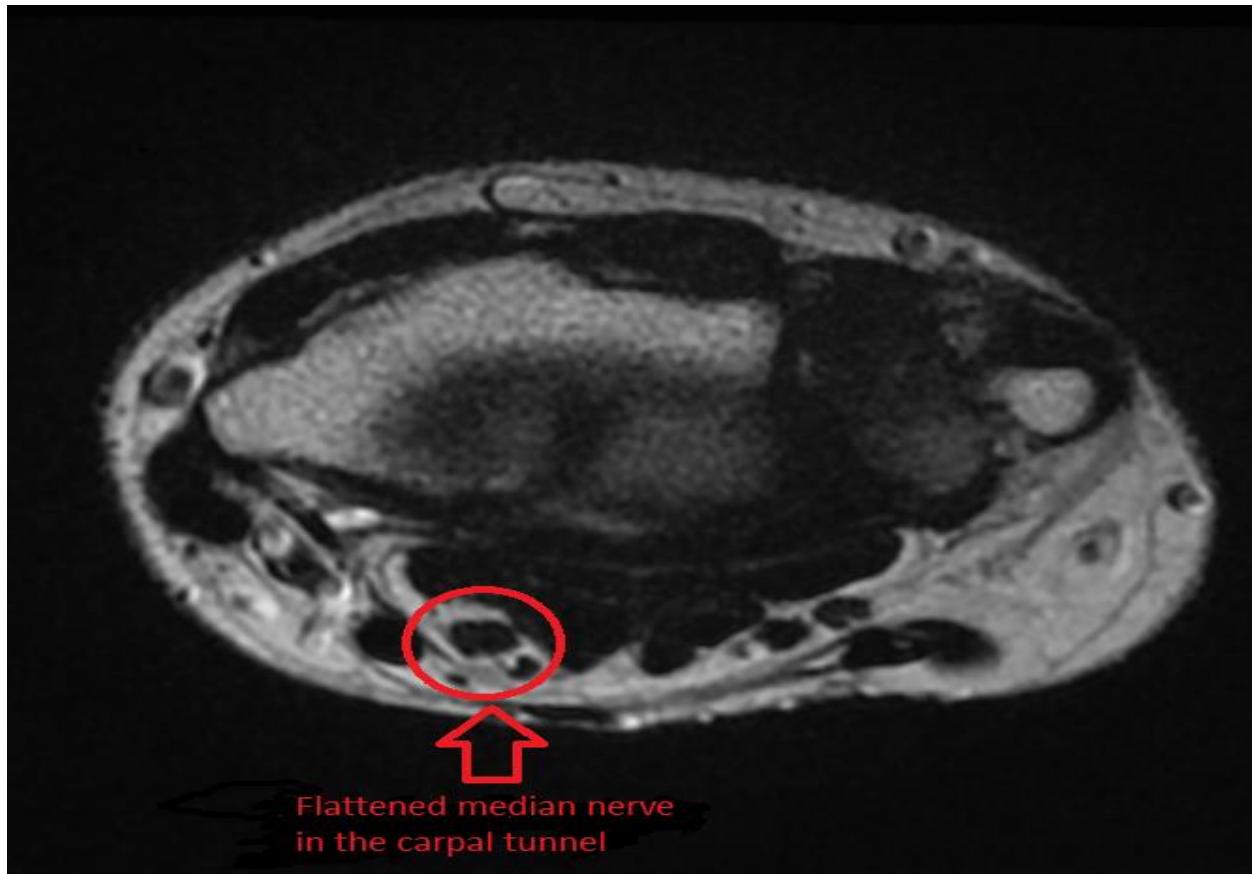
Preoperative MRI - flattened aspect of the median nerve.
